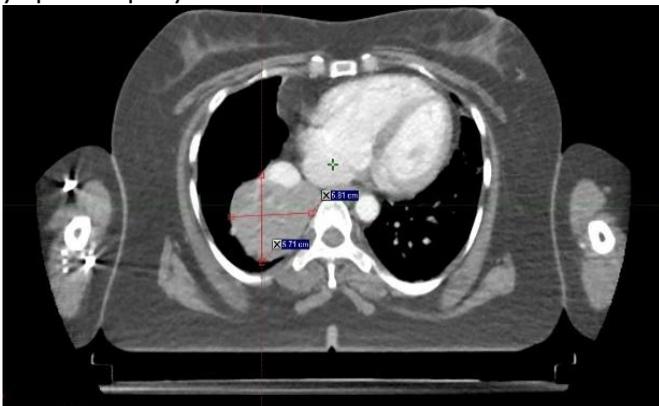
Contrast enhanced CT Thorax (Axial view) - Evidence of a well circumscribed lesion measuring 5.7x5.8cm in right hemi-thorax.
